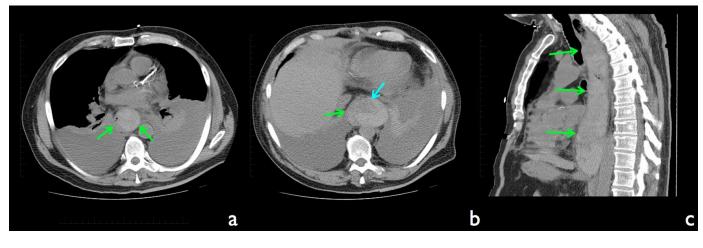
73-year-old man with intramural esophageal hematoma. (a) Axial non-contrast CT of the chest demonstrates a high attenuation mass in the proximal esophagus consistent with an esophageal hematoma measuring 5.0 x 5.7 x 24.9 cm (anteroposterior (AP) x transverse (TR) x cranio-caudal (CC)) (green arrows). (b) Axial non-contrast CT of the chest demonstrates significant mural thickening of the esophageal wall (green arrow) as well as a high attenuation mass in the distal esophagus (blue arrow). (c) Para-sagittal non-contrast CT of the chest demonstrates the extension of the high attenuation mass along the mid to distal esophagus (green arrows). (Protocol: 436 mA, 120 kVp, 5.0 mm thickness)
